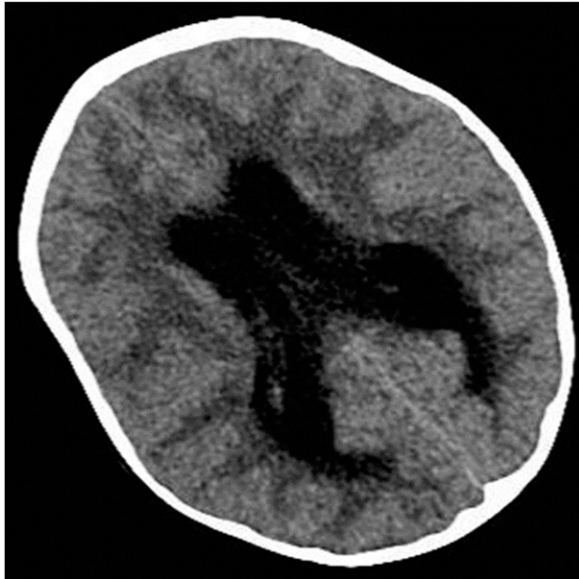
Computed tomographic scan of the head of the patient demonstrating tetra-ventricular hydrocephalus.
